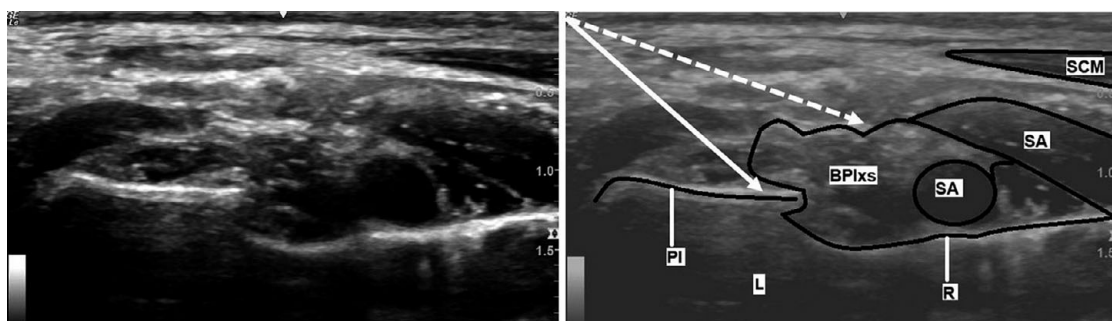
Ultrasound appearance of the brachial plexus in the supraclavicular region (BPIxs); subclavian artery (SA), pleura (PI), lung (L), rib (R) and sternocleidomastoid muscle (SCM).
